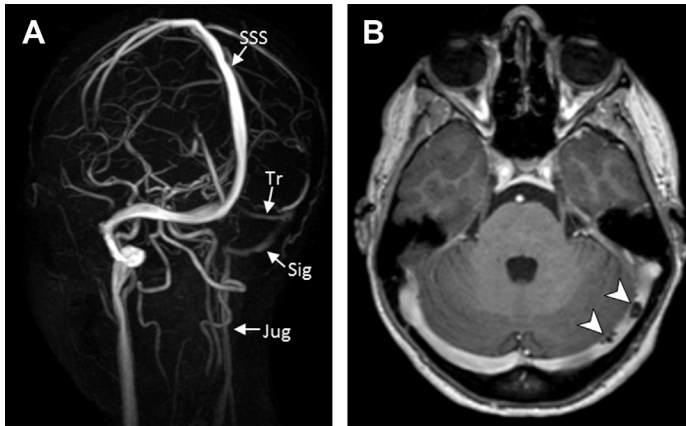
MIP reconstruction of 3D PCA (A) shows low-intensity flow signal in the left transverse (Tr) and sigmoid (Sig) sinuses and in the left jugular vein (Jug). Normal flow is seen in the contralateral identical vessels and in the superior sagittal sinus (SSS). These findings are due to anatomic variation, most likely unilateral hypoplasia or slow flow. However, the contrast-enhanced T1-weighted (B) images show two well-defined, rounded filling defects in the transverse sinus (arrowheads). These are characteristic to arachnoid granulations, but in the presence of the PCA findings they may be mistaken for sinus thrombosis, although their presence is coincidental.
